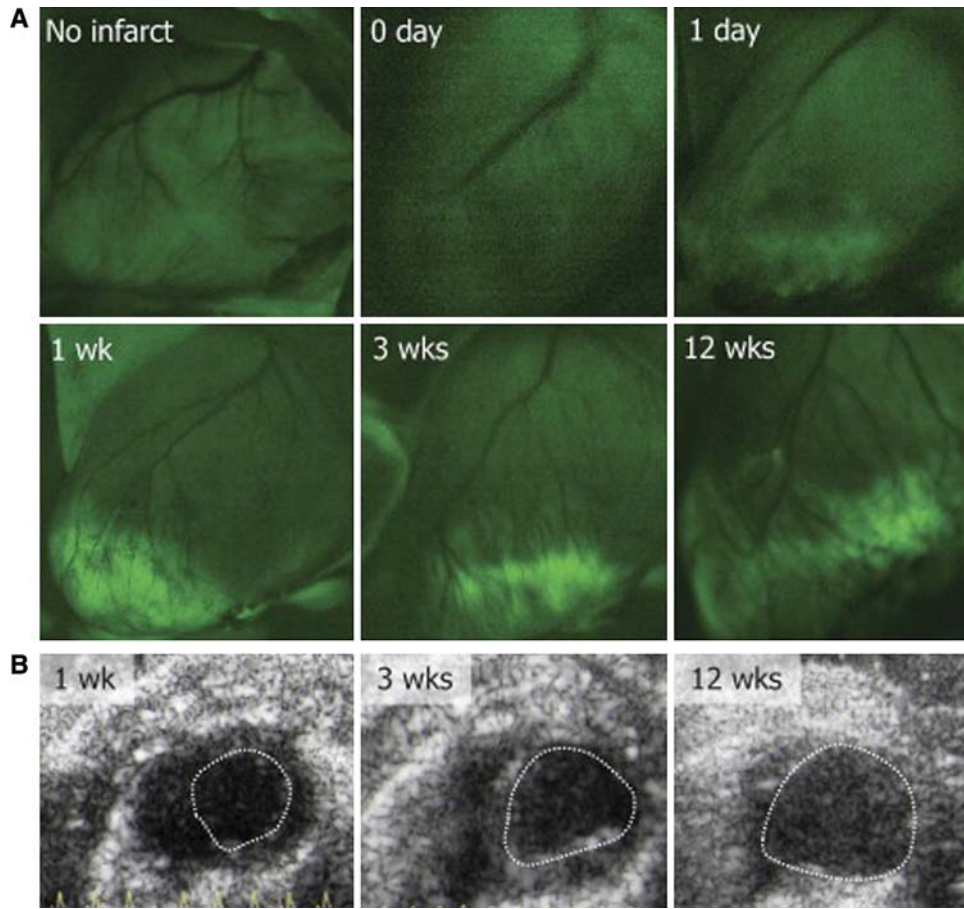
A, Imaging data show the uptake of the fluorescent AT1 receptor-targeted tracer at different time points after MI. The uptake peaks at 1 week post AMI, and then gradually decreases over time. In B, the concomitant echocardiographic data are shown, indicating a clear increase in LV end diastolic diameter.
